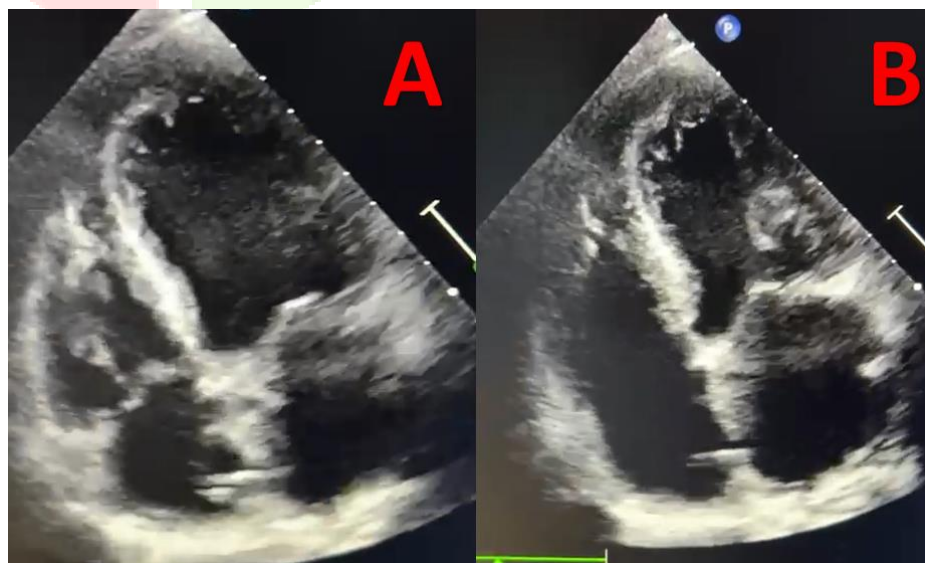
Trans-thoracic echocardiography (TTE) conducted after one month of pacemaker placement showed a standard apical 4 chamber image, which indicated the presence of normal end-diastolic (A) and end-systolic (B) dimensions, together with a conserved ejection fraction of 55%.
